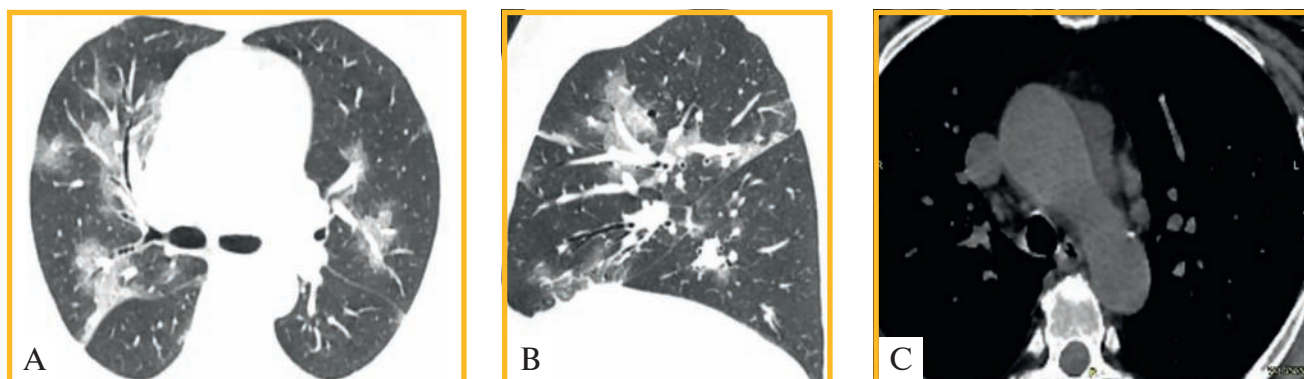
Multispiral computed tomography of the chest (1 mm slices) on the 4th day of clinical symptoms of COVID-19 pneumonia: A, B, Axial slices. The sagittal reconstruction shows multilobar polysegmental lung damage, pericarditis, high density lesions associated with the ground glass opacities, air bronchogram symptom; C, Indurated and enlarged lymph nodes in the aortic window in the region of aortic arch
